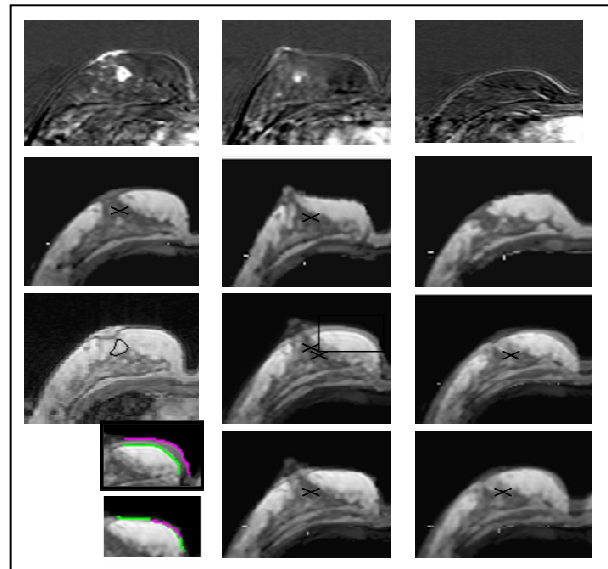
Registration of segmented breast MR images for assessing chemotherapy response
